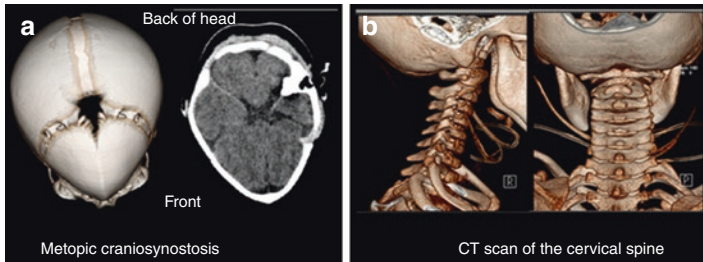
3D CT scan of the skull showing fused metopic suture (a). (b) Shows a 3D CT scan of the neck. Note that a neck CT is often obtained along with the head in severe trauma: remember ABC and “s”. The ‘s’ is for the cervical spine!
